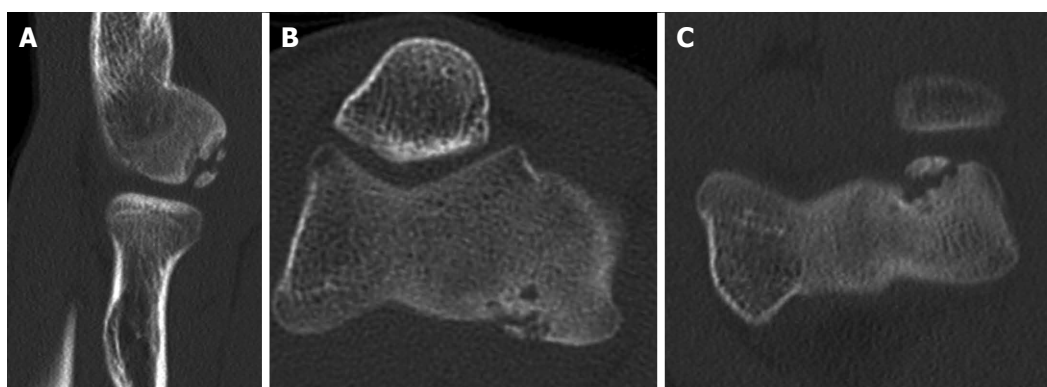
Computed tomography scans showing capitellar osteochondritis dissecans (A-C).
